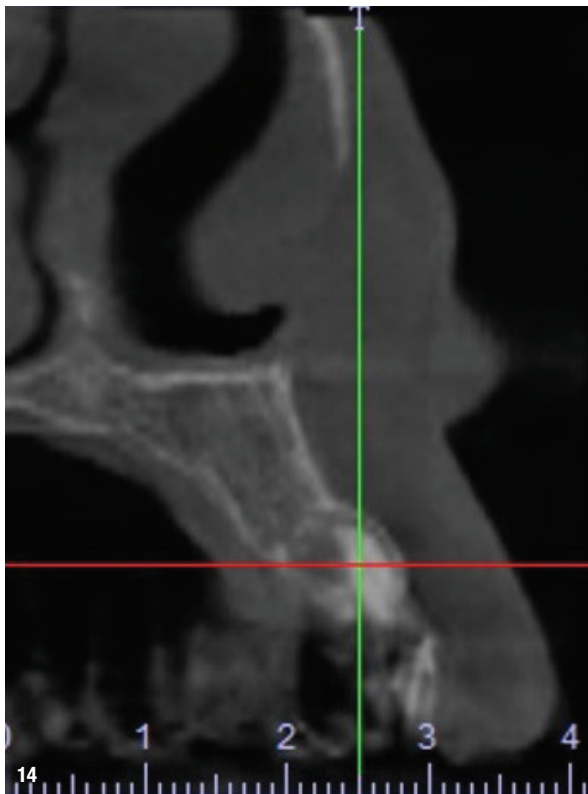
CBCT image showing periapical periodontitis.
